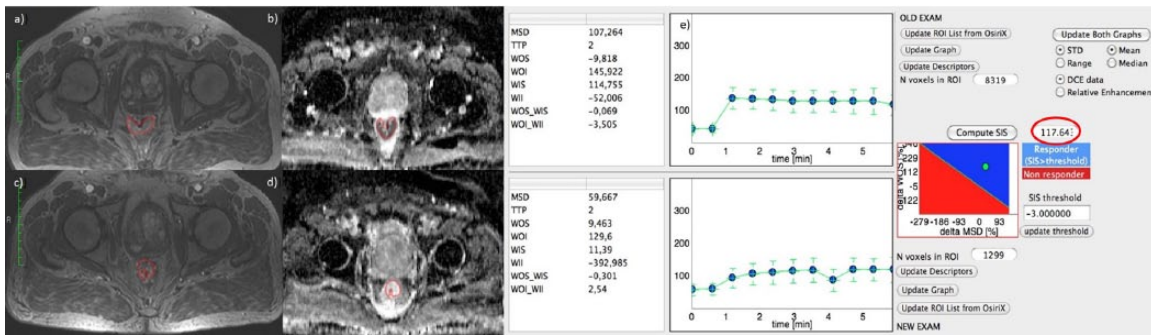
Dynamic contrast-enhanced magnetic resonance imaging and standardized index of shape analysis for a complete pathological responder patient.
